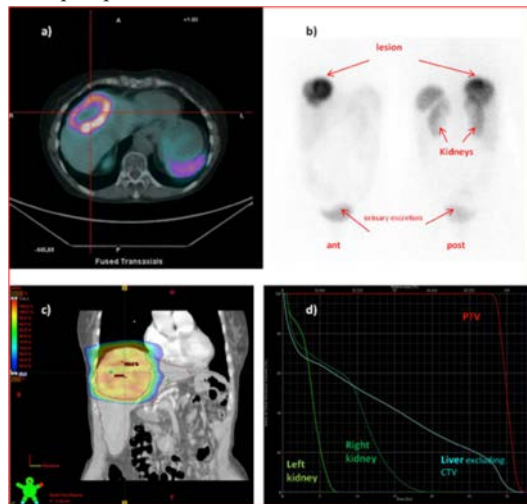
Dosimetry of adjuvant RT (30 Gy, 10 fractions, VMAT) in a patient with liver mets (200 ml) from pancreatic NET, after relapse to PRRT (27.9 GBq of LuD). Mean doses were: for PRRT, $k=17$ Gy, $RM=1.1$ Gy, $L=1.4$ Gy, clinical target volume (CTV)= 230 Gy; for RT: $K_{right}= 8.3$ Gy, $K_{left}= 3.8$ Gy, $liver-CTV=12.8$ Gy, $CTV=30$ Gy. Both treatments were well tolerated (RM grade I; K, L absent). a) fused SPET/CT image (axial) and b) planar whole body (anterior, posterior) images of LuD; c) isodose distribution in a coronal plane; d) Dose Volume Histograms for the planning target volume (PTV) and OARs. The patient is alive with no toxicity at 5 yr follow-up.
